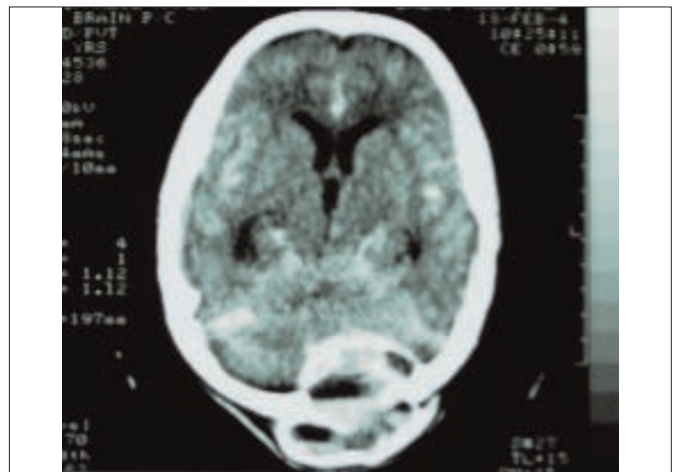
CT scan showing large expansile lytic lesion with internal septation in occipital bone.
